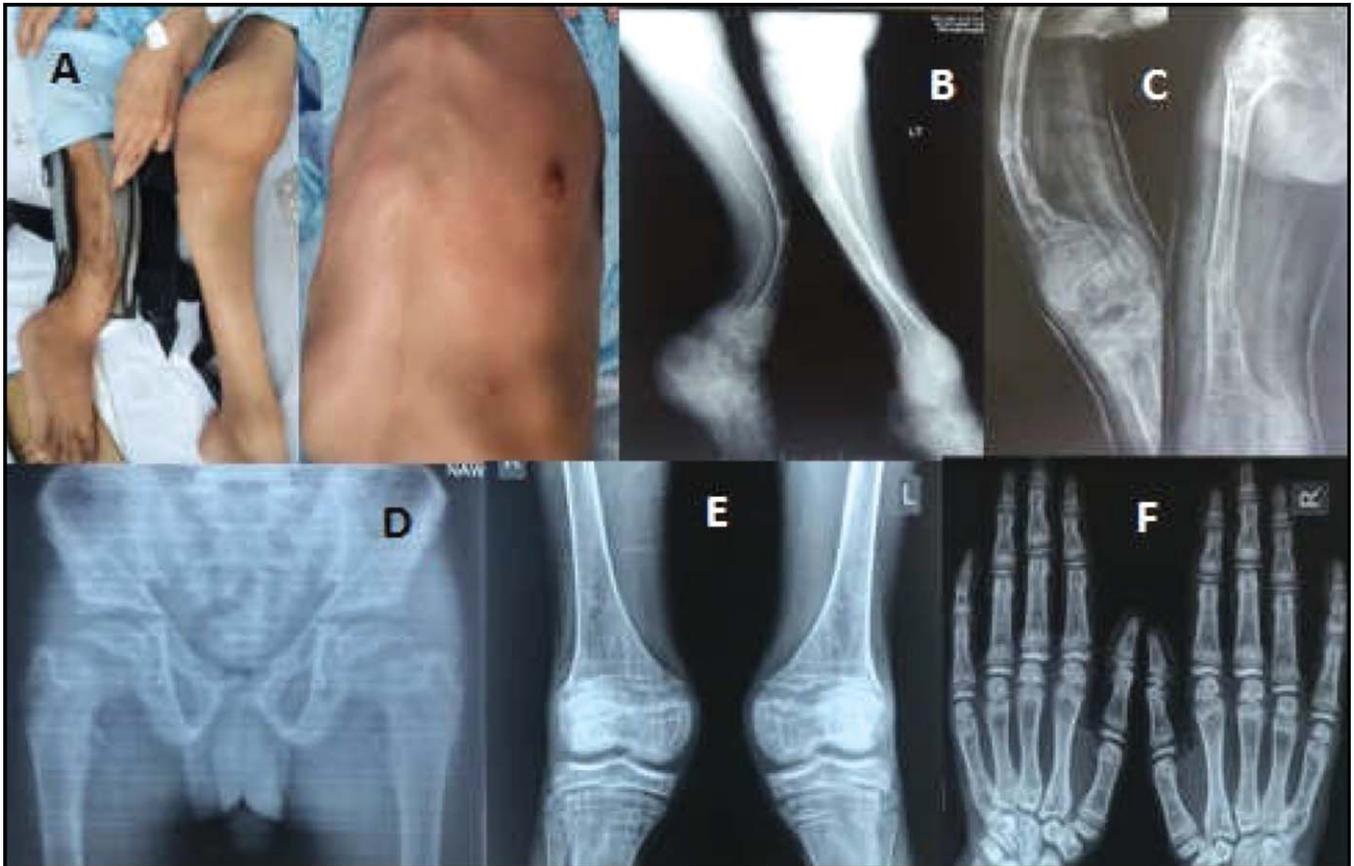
A) Bowing of legs, prominent chest and multiple bone deformities (Case 1). B & C) X-ray of legs showing multiple fractures, generalized osteopenia, and looser zones (Case 1). D, E & F) Radiological features of metabolic bone disease (Case 2).
